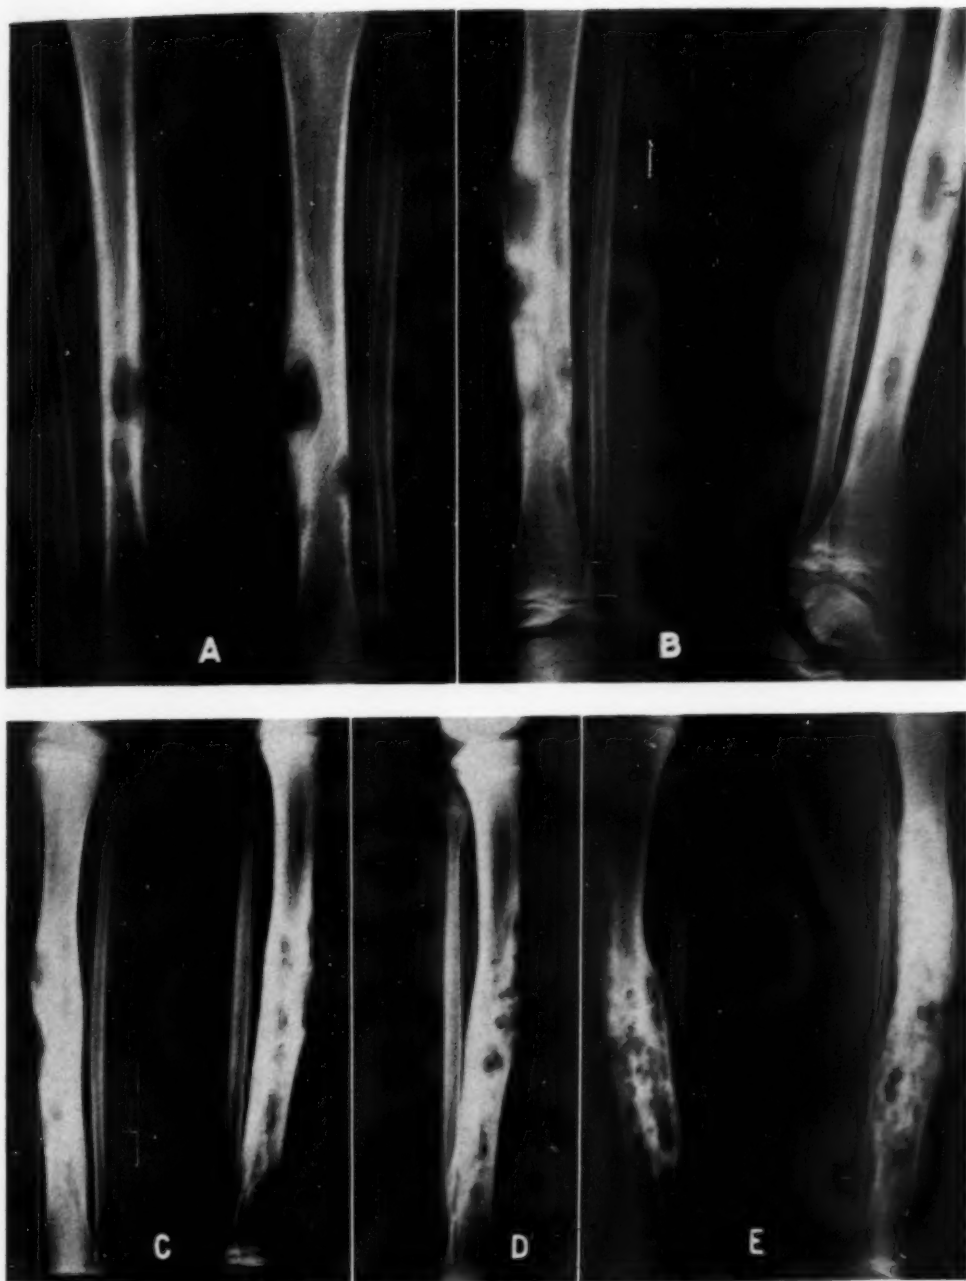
Case 1. A. Lesion in tibia at time of original admission, at six years of age. Note cyst-like areas in bone with poorly defined margins, eccentric location with cortical encroachment but no penetration, and beginning expansion. B. At age of seven years. Note progression, with new lesions in spite of surgery and roentgen therapy; larger lesions show "smudge." C. Age nine years: lesion progressing with increased deformity; note dense bone surrounding "cystic" areas. D. Age twelve years: few new areas of involvement in distal diaphysis showing no dense border or "smudge", while adjacent older lesion shows both features; periosteum over proximal lesions thin but intact. E. Age eighteen years: lesion more extensive, with increased deformity and expansion.
